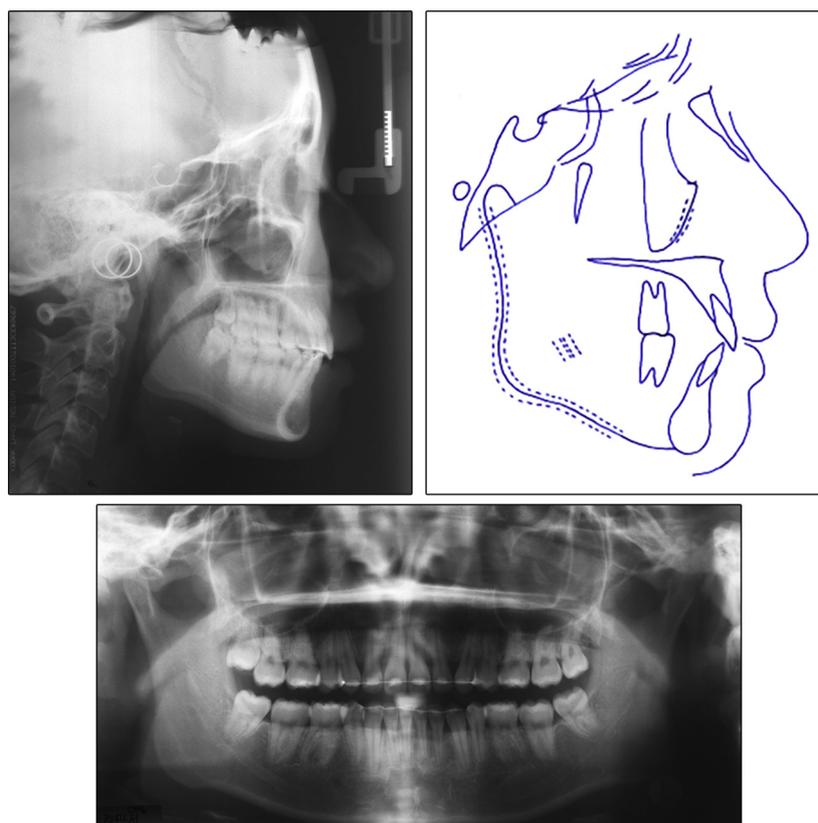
Radiographs 14 months after debonding.
